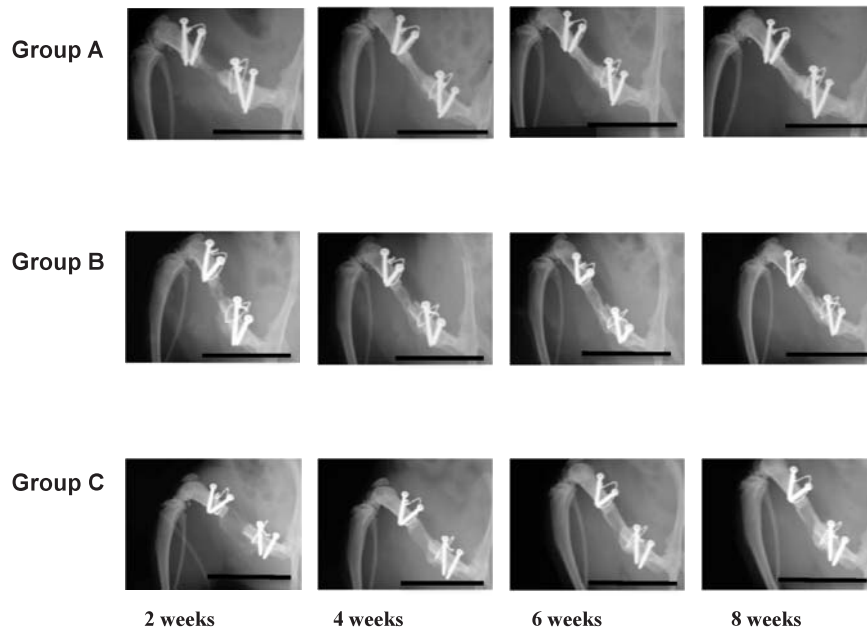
Radiographic findings.
